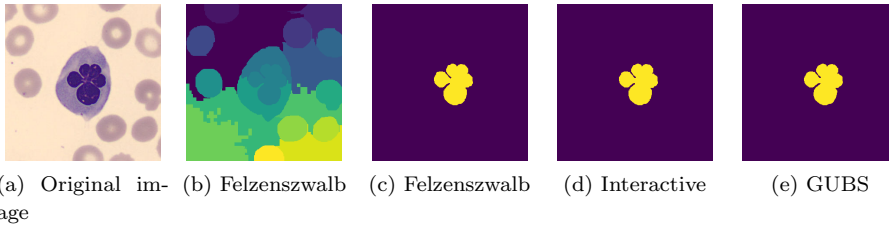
Nucleus segmentation of erythroblast by using MST-based methods. (a) image showing a WBC erythroblast (with a nucleus) and red blood cells (RBCs) seen in the background. (b) and (c) Felzenszwalb segmentation ($k=0.3$, Minimum component size =2000), (d) segmentation by MST approach presented in paper B (originally developed for segmenting brain tumors), (e) segmented nucleus using GUBS (originally tested on segmenting brain from 3D MRI). For GUBS, the values less than 0.3 are the sampled points in the background and values greater than 0.7 are sampled points in the ROI. Original image from [1].
